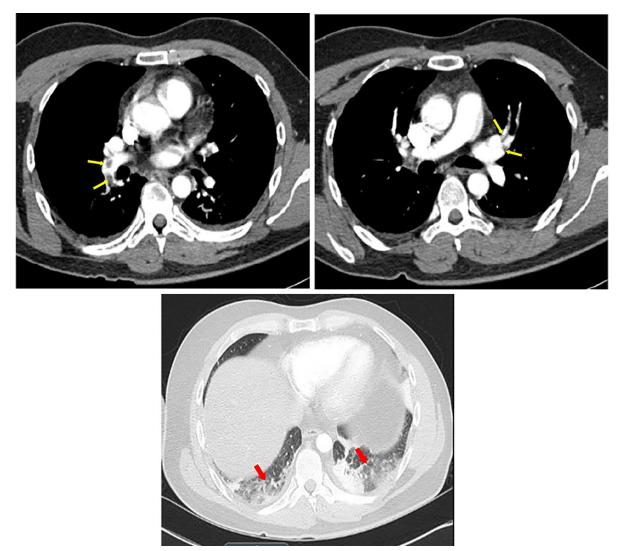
Computed tomographic (CT) angiography of the chest
